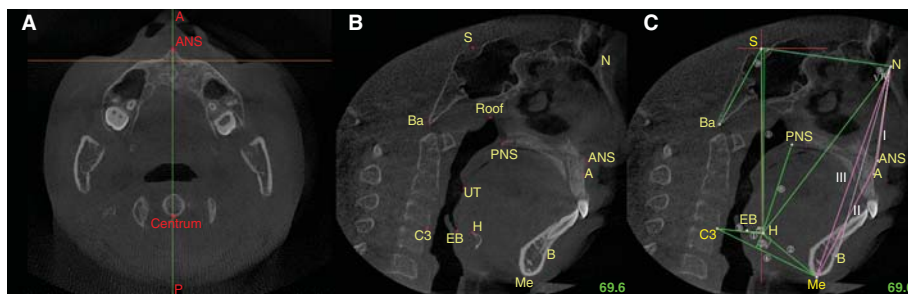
Cone beam computed tomography (CBCT) images were reoriented to the Frankfort horizontal (FH) plane. (A) The mid-sagittal plane was fixed through the center of the anterior nasal spine (ANS) and was established at the posterior mid-point of the spine. (B) In the mid-sagittal view, 13 landmarks were defined for the following analysis. (C) The measurements of hyoid bone and facial pattern were taken by 11 linear and three angular measurements.
